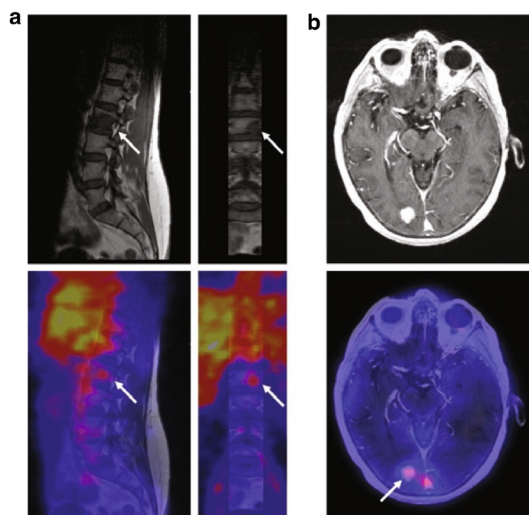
Examples of fusion images from HER2 PET and MRI scans. (a) In a vertebral metastasis seen on MRI but unapproachable for biopsy, HER2 status was revealed by ^{89}Zr -trastuzumab uptake on PET imaging. (b) Example of HER2-positive brain lesion undetected by conventional scans, revealed by ^{89}Zr -trastuzumab PET imaging, and subsequently confirmed by MRI. Arrows indicate lesions. HER2, human epidermal growth factor receptor 2; MRI, magnetic resonance imaging; PET, positron emission tomography; ^{89}Zr , zirconium-89.
